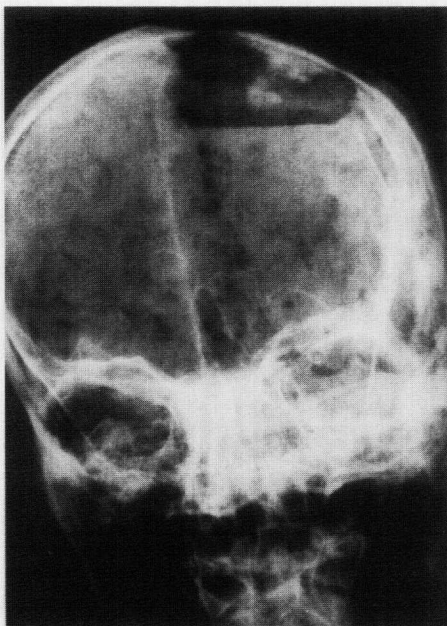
Postmortem radiograph of the cranium showing large radiolucent defect on the left parietal.
